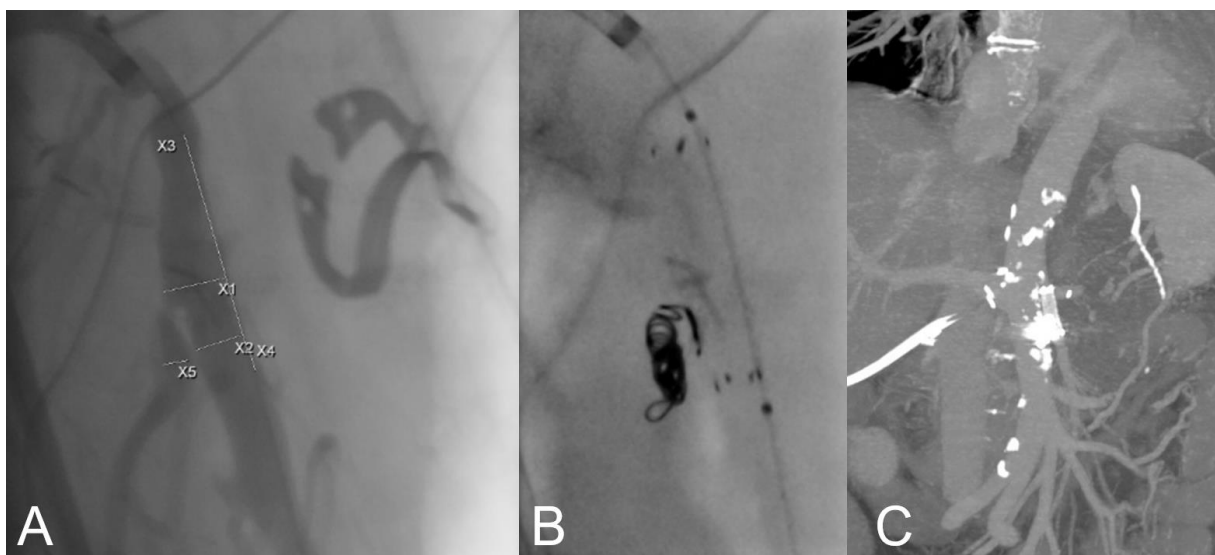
Figure Supplement 2: A patient presents with a pseudoaneurysm near a jejunal arcade following Whipple surgery for pancreatic carcinoma, complicated by intraluminal blood leaks. The proposed approach includes: A) Planning angiography, B) A combined procedure of coil embolization and stent graft implantation, and C) Post-interventional CT imaging.
